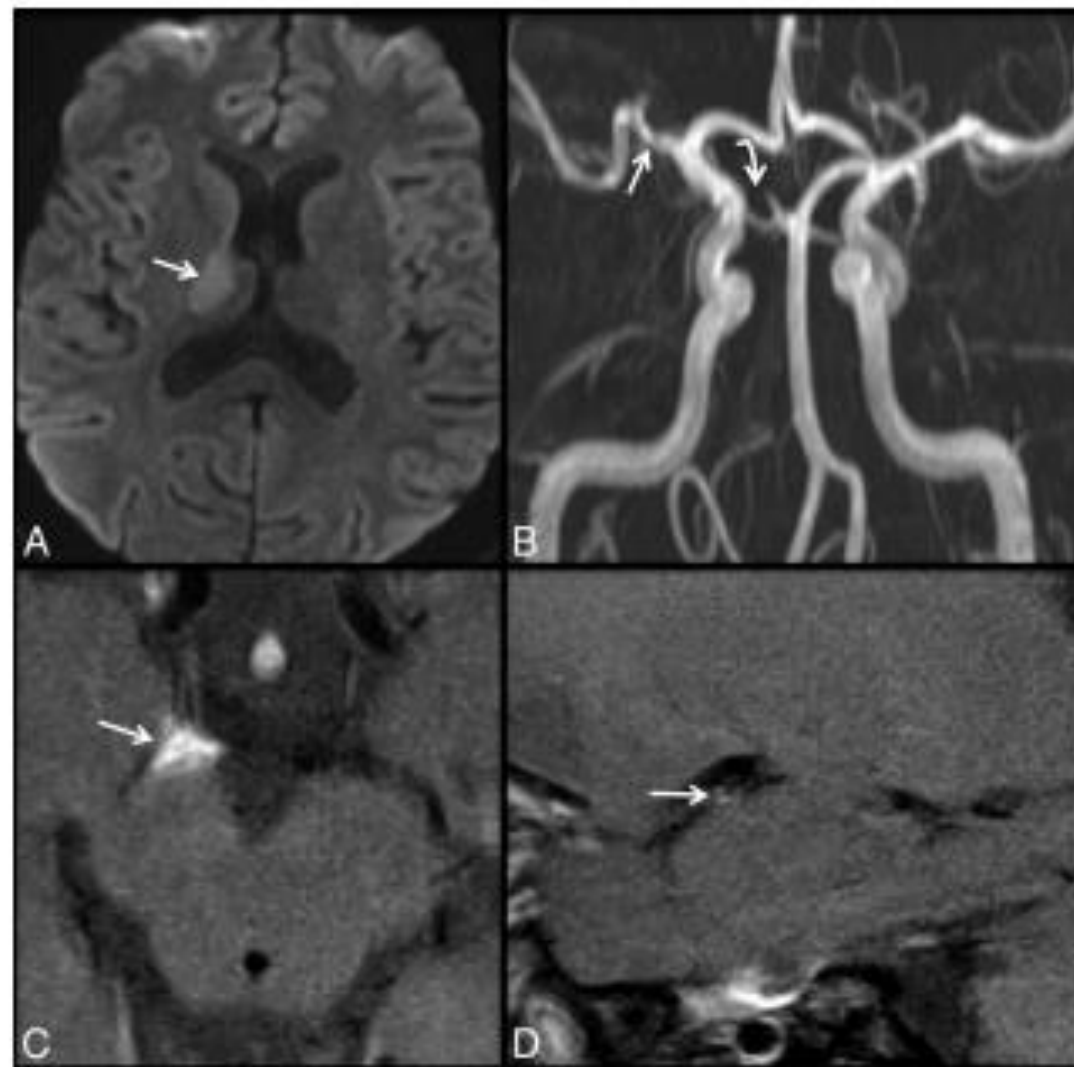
A 35-year-old man with a history of Behçet vasculitis who presented with left-sided weakness. DWI (A) demonstrates an acute infarct involving the right thalamus and posterior limb of the internal capsule (white arrow). Coronal 3D reformat of TOF MRA (B) reveals irregularity and narrowing of the M1 arterial segment of the right MCA (white arrow) and occlusion or high-grade stenosis of the P1 arterial segment of the right PCA (curved white arrow). On axial T1 postcontrast high-resolution VWI (C), there is prominent enhancement and enlargement of the right posterior cerebral artery (white arrow). Sagittal T1 postcontrast VWI (D) demonstrates typical tram-track, circumferential enhancement of the right M1 MCA (white arrow), consistent with vasculitic inflammation.
